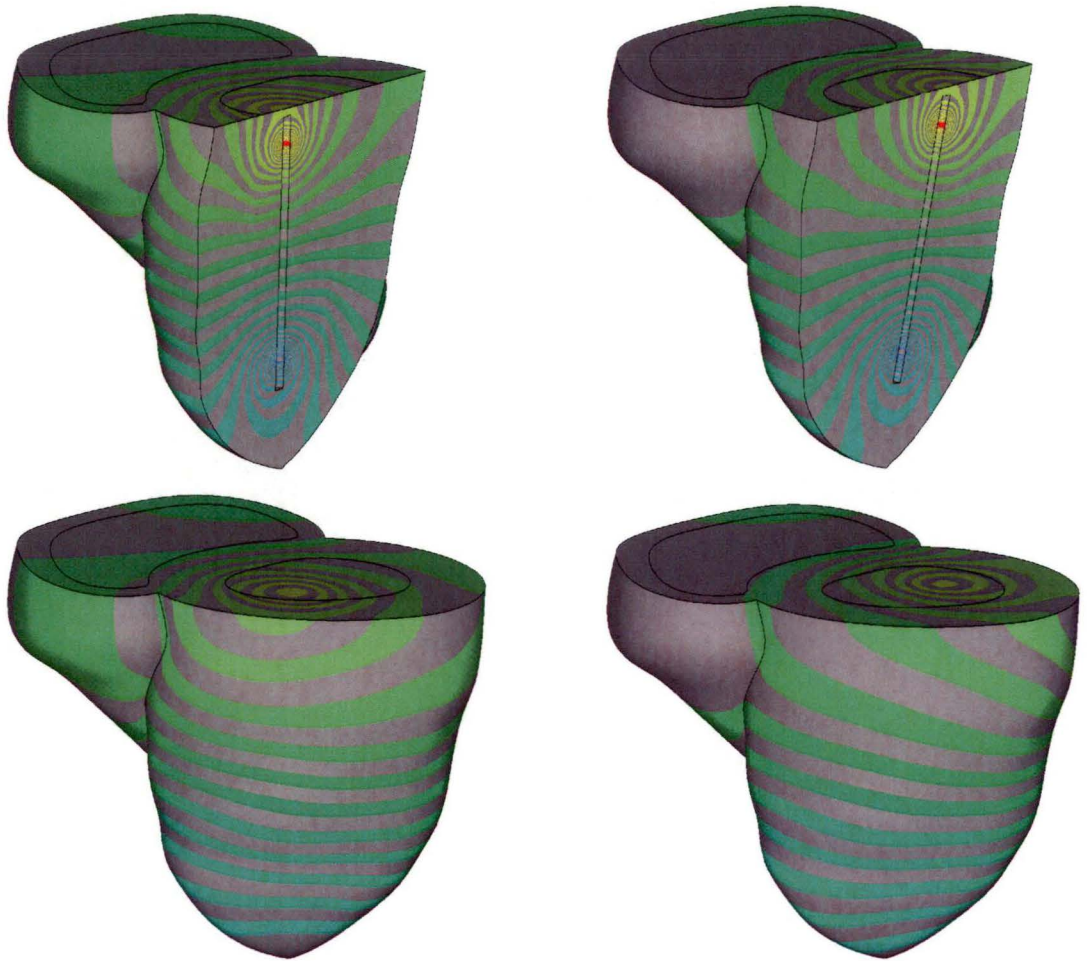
Off centre (pulmonary artery - liver direction) left ventricle catheter voltage contours in tagged MRI model at end systole for blood conductivity/myocardium conductivity = 2.75.
